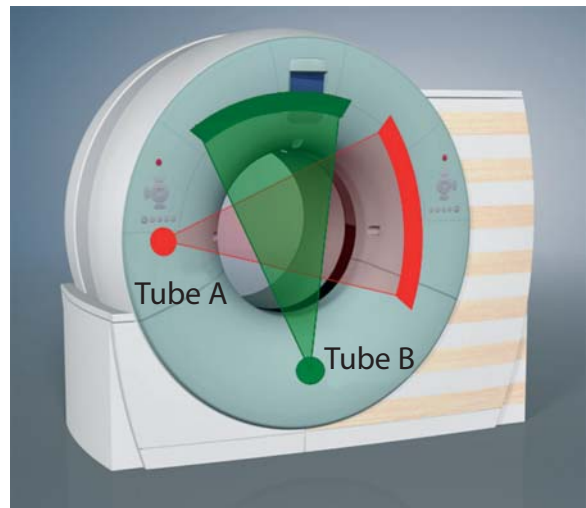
A dual-source CT system with two tubes and two corresponding detectors offset by 90° (SOMATOM Definition, Siemens, Forchheim, Germany). A scanner of this type provides temporal resolution roughly equivalent to a quarter of the rotation time, independent of the patient's heart rate
